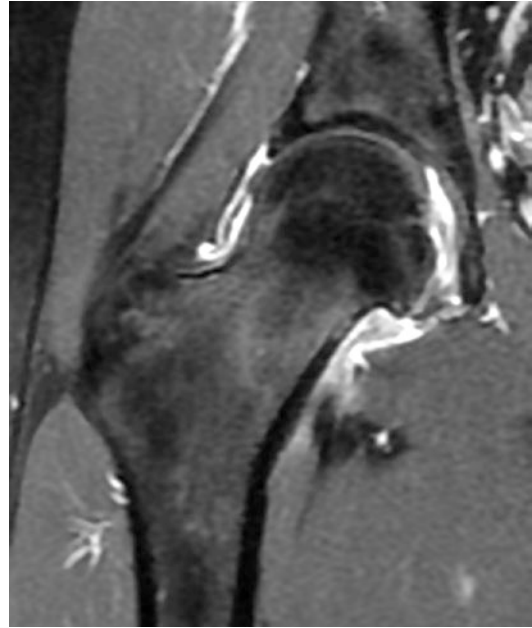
Pathognomonic hemosiderin deposition signal of a villonodular synovitis in T1-FS gadolinium MRI coronal view of the right hip
